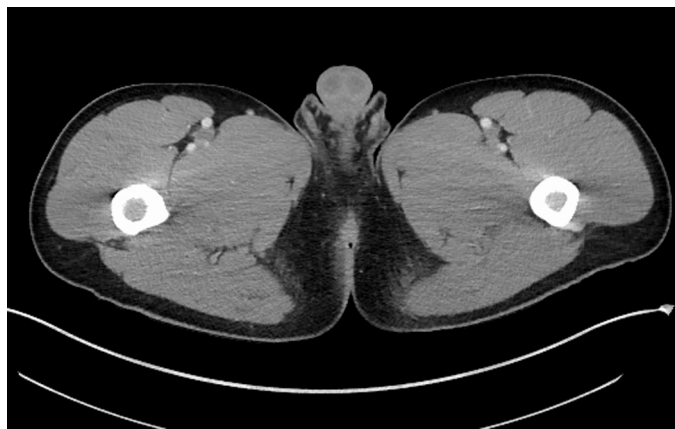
Initial computed tomography of the pelvis revealing mild inflammation of the perianal skin and tissue surrounding the rectum.
